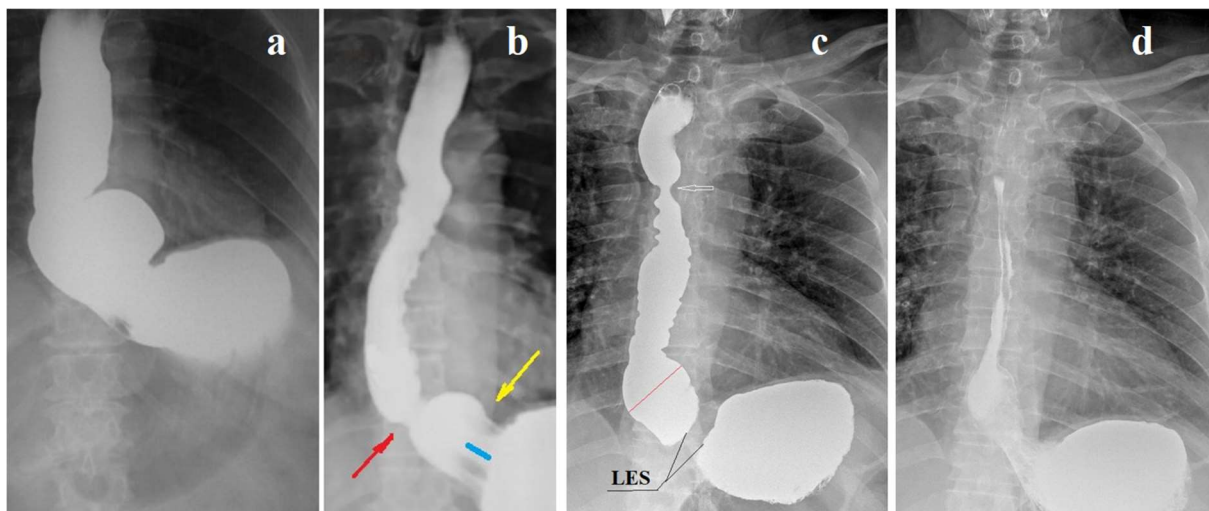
Radiographs of patients with chalasia EGJ. (a-b). A 68-year-old woman has been ill since her youth. Sometimes, while bending over, food residues eaten the day before appearing in the mouth. She does not consume foods containing lactose, which causes heartburn, and takes 20 mg of PPI per day, which is enough to prevent heartburn. (a). During maximum provocation, a sharp dilation of the esophagus is visible, especially in its ampullary part, as well as a sharp dilation of the hiatus. (b). After 5 minutes, free reflux from the stomach into the esophagus is determined. (c-d). A 72-year-old man had with complaints of a debilitating
